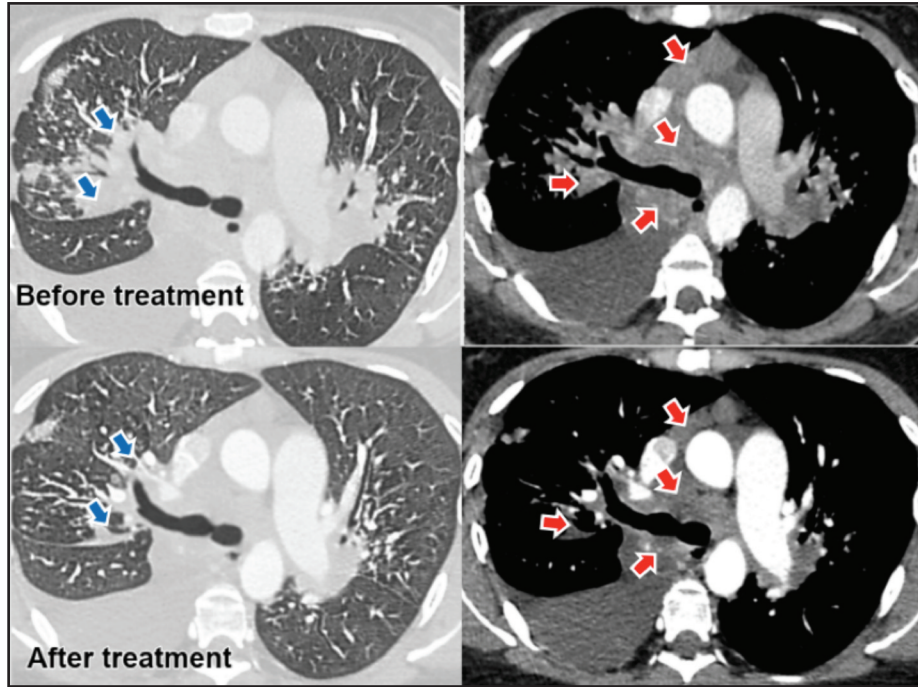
Pre and post treatment CT thorax image showing resolving peribronchovascular nodules and consolidation (blue arrow) and reducing sizes of station 3A, 4L ,4R ,7 and 10R and mediastinum lymph nodes (red arrow).
